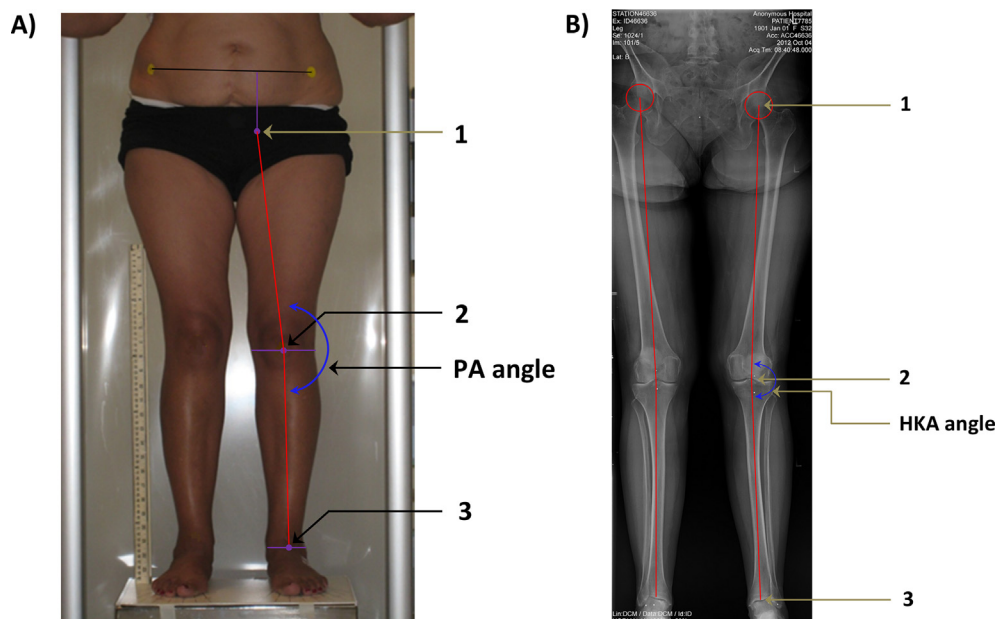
Participant set-up and lower-extremity angle calculations. (A) The PA angle, measured from a pelvis-to-floor photograph. 1. Estimated center of the hip [32% of the inter-ASIS distance medial to, and 34% of this distance distal to the ASIS]. 2. Estimated center of the knee (the mid-point of a horizontal line drawn across the knee where the medial contour of the soft tissue of the knee changes from convex to concave). 3. Estimated center of the ankle (the mid-point of a line drawn horizontally at the crease where the ankle meets the foot). (B) The HKA angle, measured from a full-length LE radiograph. 1. Center of the femoral head. 2. Tibial interspinous groove. 3. Center of the tibial plafond.
